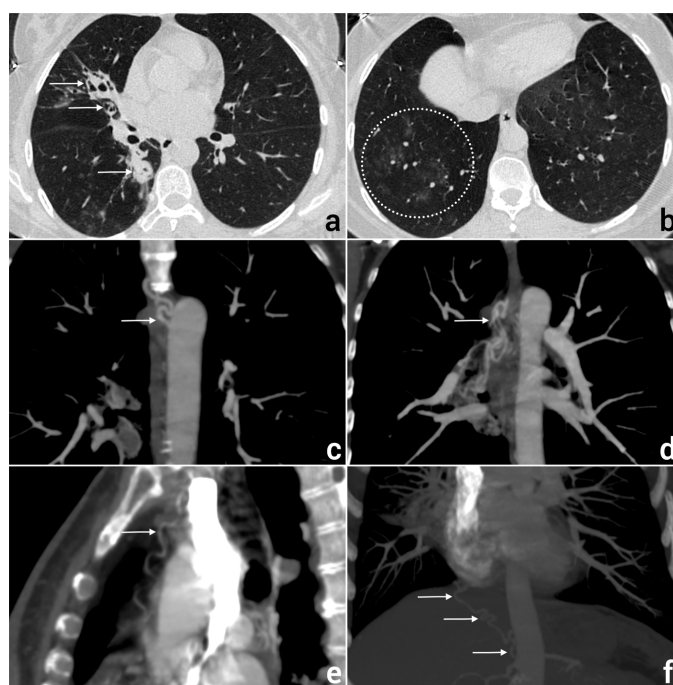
Images of a 61-year-old female patient presenting with hemoptysis, who underwent preprocedural computed tomography (CT) angiography and was subsequently referred to interventional radiology for bronchial artery embolization. a) Axial thorax CT image shows right lung bronchiectasis (white arrows). b) A more inferior axial section demonstrates patchy ground-glass opacities consistent with alveolar hemorrhage (broken white circle) in the patient presenting with hemoptysis. c, d) Coronal maximum intensity projection (MIP) images show hypertrophied and tortuous right intercostobronchial and right bronchial arteries, respectively. e, f) Sagittal and coronal MIP images demonstrate hypertrophied and tortuous right internal mammary and right phrenic artery branches, respectively
